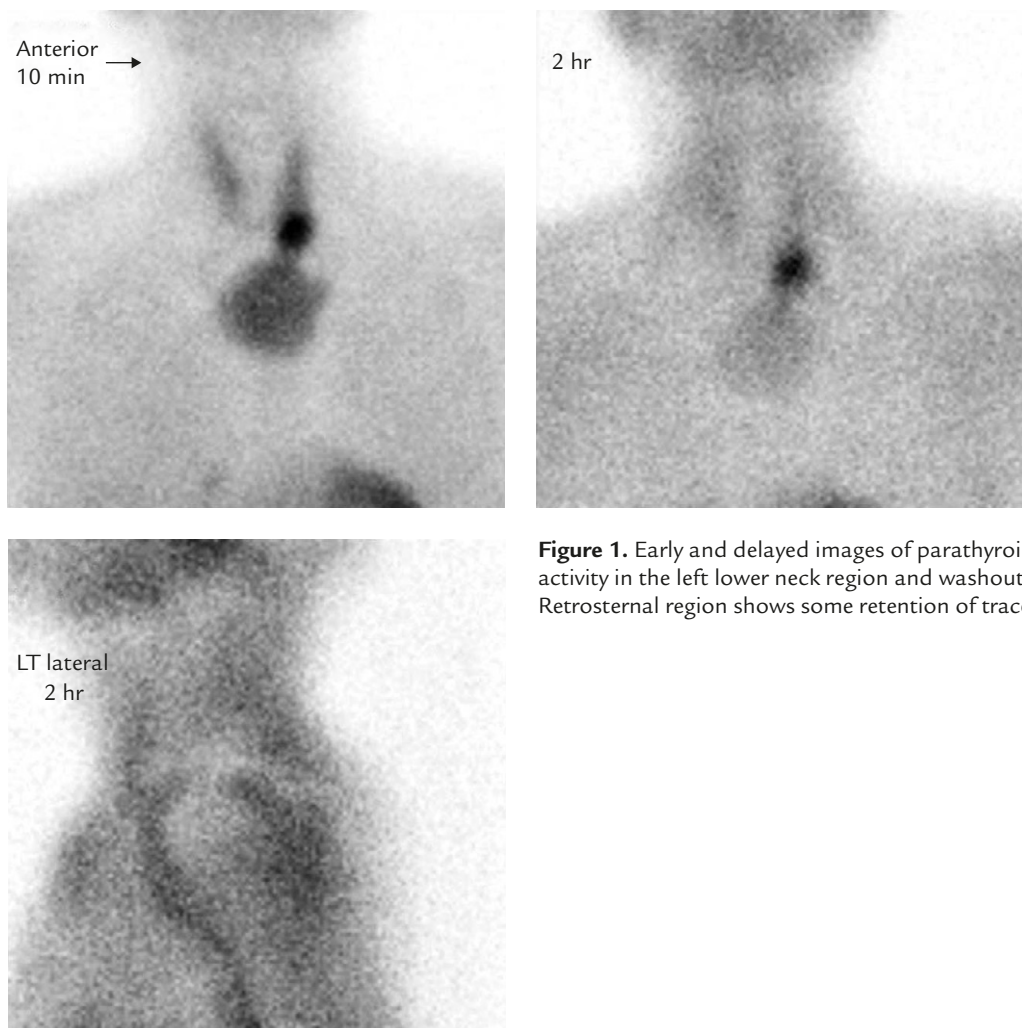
Early and delayed images of parathyroid scintigraphy show persistent activity in the left lower neck region and washout of activity from thyroid lobes. Retrosternal region shows some retention of tracer.
